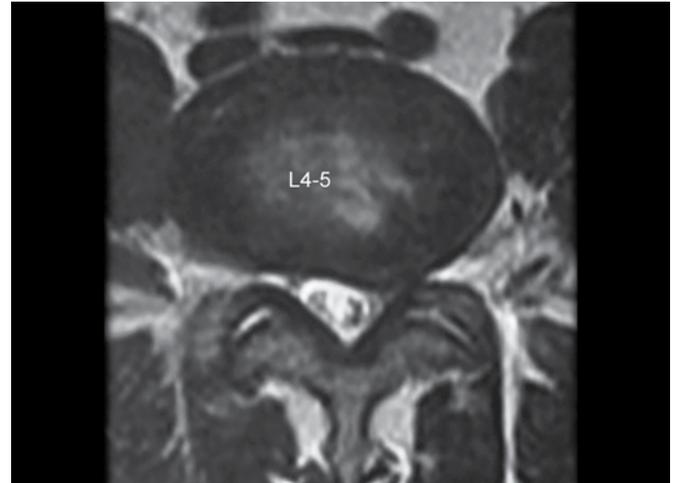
Axial T2-MR image showing the large left-sided paramedian disk prolapse compressing the traversing root and the dural sac
